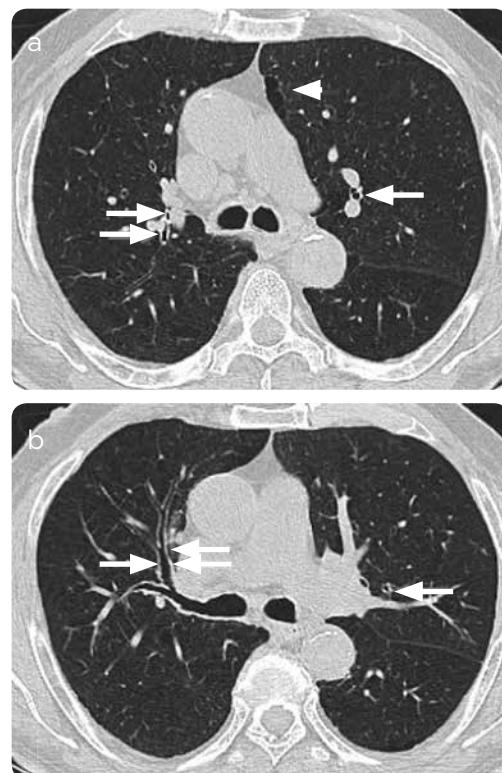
Chest CT scan, window of lung a) in carina and b) in source bronchi: some areas of thickening of bronchial walls related to chronic bronchitis (arrows) in patient with a history of heavy smoking and COPD. Discrete areas of paraseptal emphysema in upper left lobe (arrowhead).
